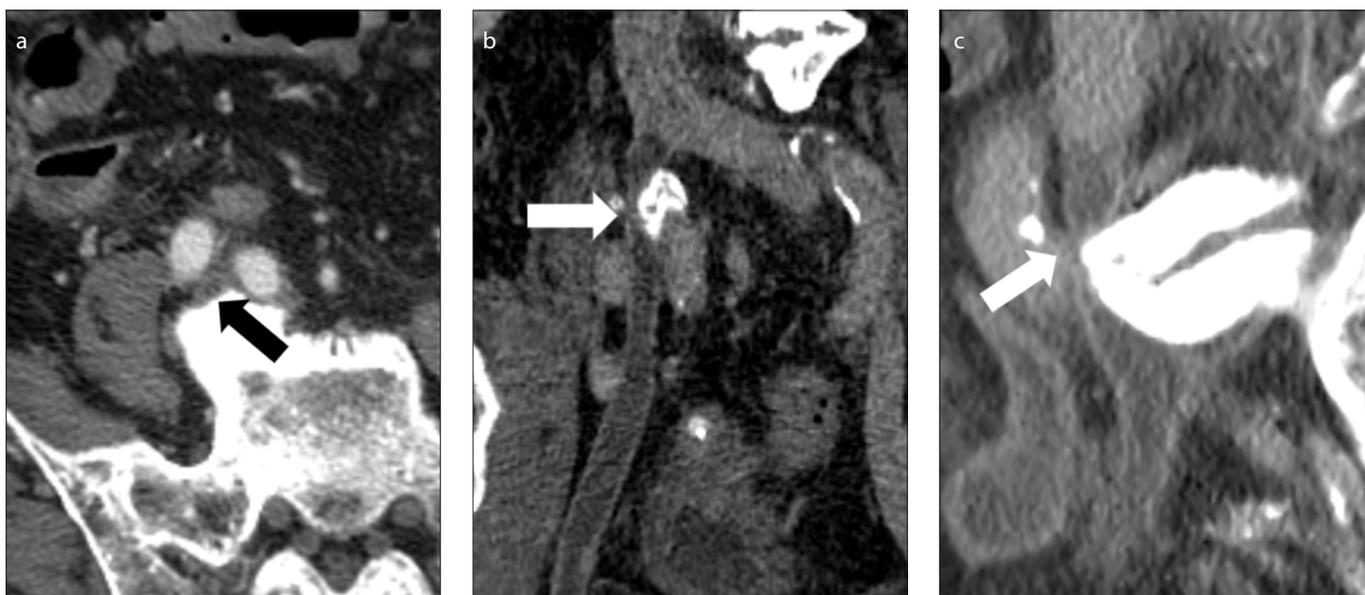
a–c. A 90-year-old man was initially brought to the emergency department because of a traffic accident. A CT venogram was performed because the patient complained of right calf pain 1 month after hospitalization. Axial (a), coronal (b), and sagittal (c) curved reconstruction images show right-sided deep vein thrombosis with right common iliac vein compression (a, *black arrow*; b, c, *white arrow*) by the right common iliac artery and prominent L5 osteophyte.
